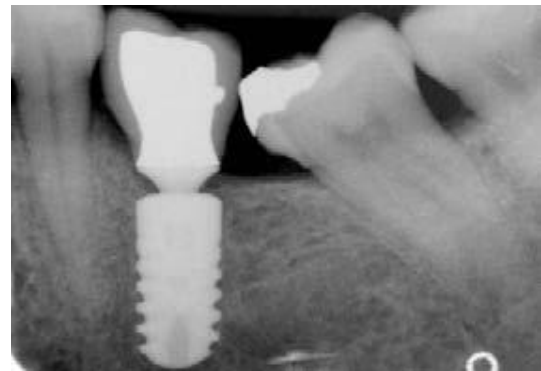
6 months following the restoration of the implant. The radiograph shows the bone level of the implant.
